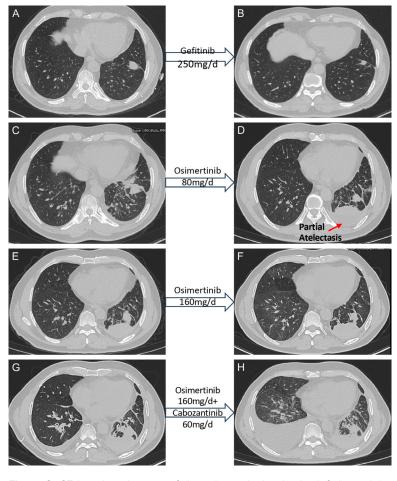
CT imaging changes of the primary lesion in the left lower lobe following treatment strategy modifications. A. CT image of the patient at the initial diagnosis. B. CT image after 3 months of treatment with gefitinib. C. CT image of the first disease progression. D. CT image after 3 months of osimertinib treatment. E. CT image of the second disease progression. F. CT image after more than 2 months of double-dose osimertinib treatment. G. CT image of the third disease progression. H. CT image after more than 1 month of double dose osimertinib combined with cabozantinib treatment.
